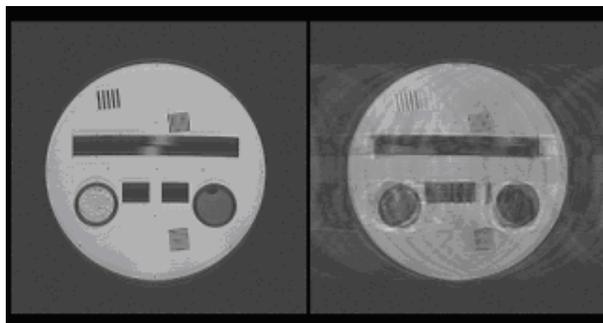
MR images with Motion artifact (right) and with proposed 3D motion correction (left). Artifacts are significantly reduced in this study.
